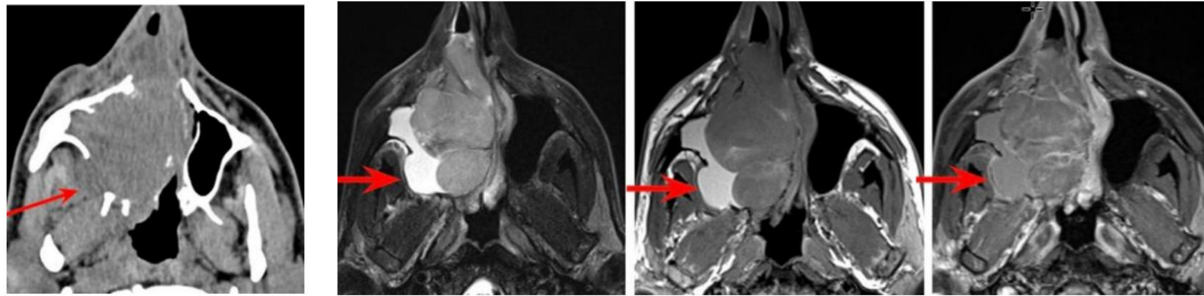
CT and MR images of right nasal melanoma. On CT, tumor and trapped secretions are difficult to differentiate, whereas MRI distinguishes tumor from T1 and T2 hyperintense secretions in the posterior lateral maxillary sinus antrum (arrows). CT: Computed tomography; MR: magnetic resonance; MRI: magnetic resonance imaging.
